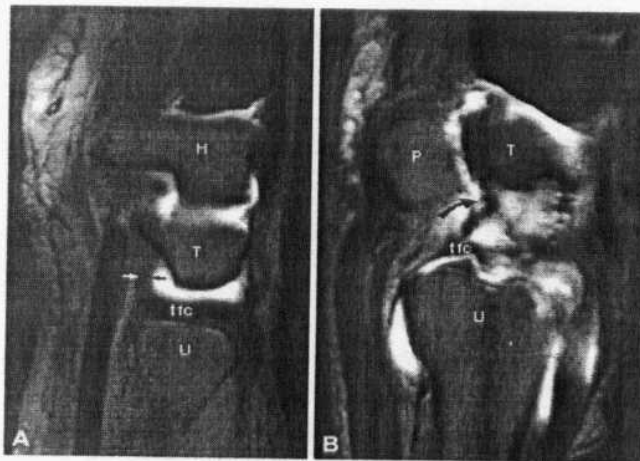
Fat-suppressed T1-weighted sagittal MR arthrographic images comparing (A) intact (black and white straight arrow) ulnocarpal (ulnolunate and ulnotriquetral) ligament with (B) avulsed osseous insertions (curved arrow) of the ulnocarpal ligaments. There is also associated tearing of the dorsal radial aspect of the TFC. Isolated avulsion of the distal ulnolunate or ulnotriquetral ligaments as described in a class IC lesion is not common. H, hamate; T, triquetrum; tfc, triangular fibrocartilage; U ,ulna; P, pisiform(Quoted from Stoller and Brody, 1997).
